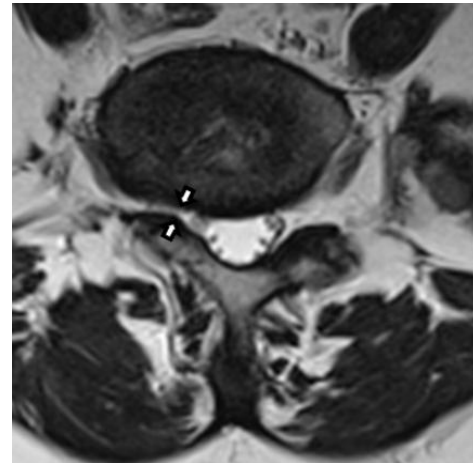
MRI image of right foraminal stenosis at L₅ - S₁ level
